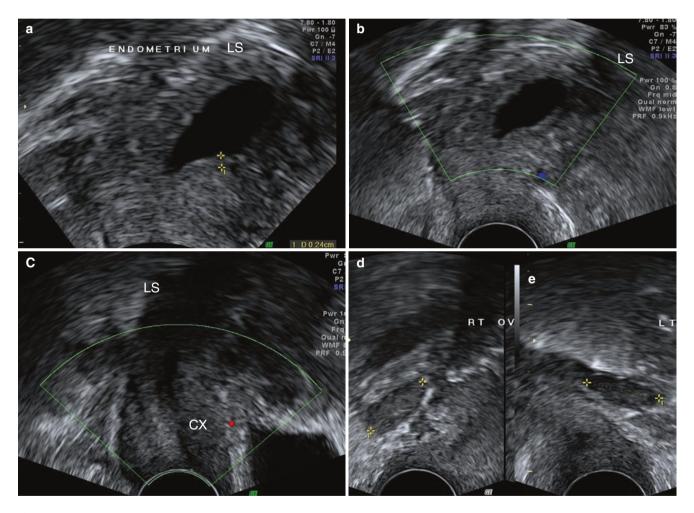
(a) Anechoic fluid collection in a postmenopausal lady with a thin endometrium. (b) No abnormal flow seen on Doppler. (c) The cervix in this case appeared normal with no evidence of local pathology as a cause for the collection. (d, e) Normal atrophic ovaries are seen
